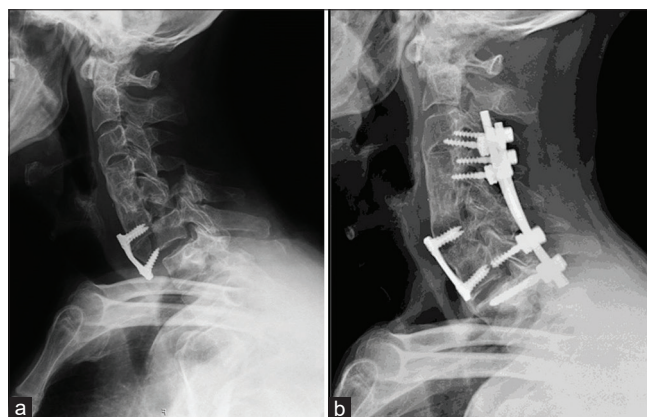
(a) One month postoperative X-ray: anteroposterior and lateral views - April 2014 - New C6-C7 dislocation. (b) Two months postoperative 360° fusion X-ray: lateral view - June 2014.
